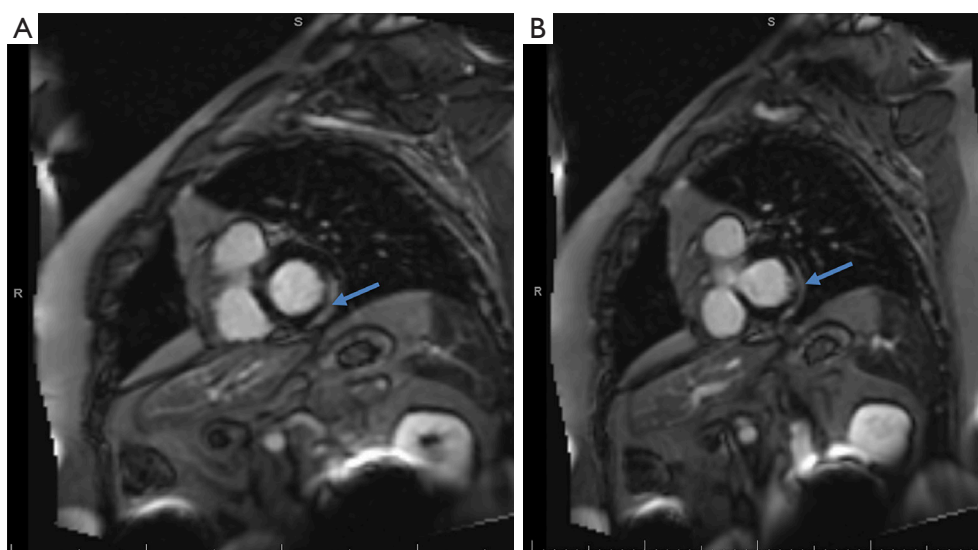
Cardiac MRI showing delayed gadolinium enhancement in the anterior lateral (A) and inferior lateral (B) segments of the left ventricle (arrows). MRI, magnetic resonance imaging.
